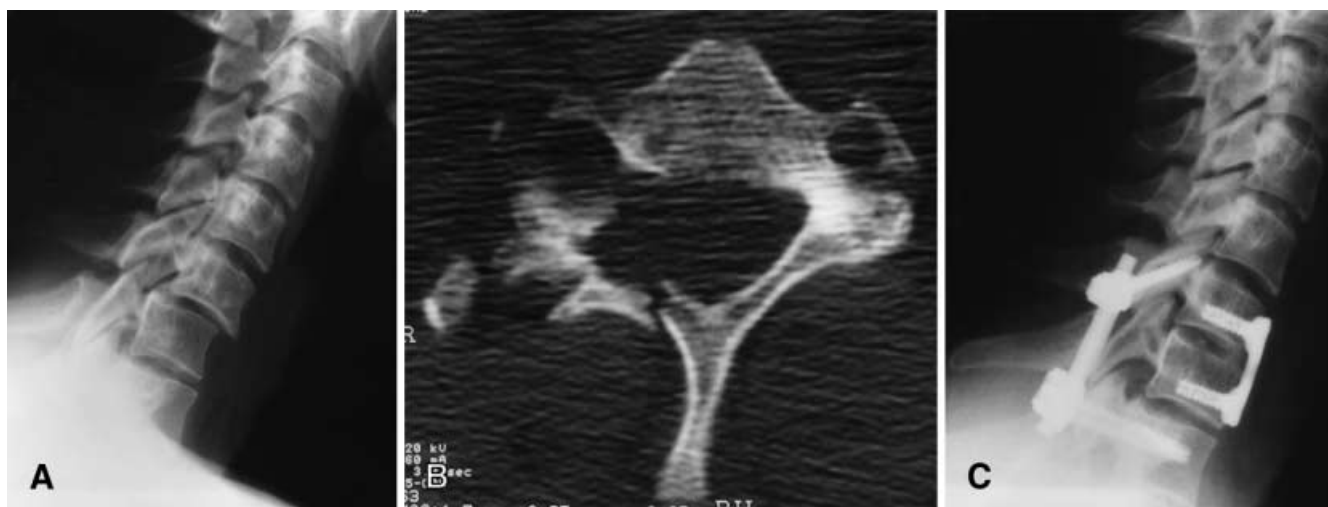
Rotational subluxation of C6/7 with unilateral fracture of articular processes and primary root damage at the same level: A lateral view, B CT section view, C postoperative result. Being fractured, the articular process of C7 could not be used
